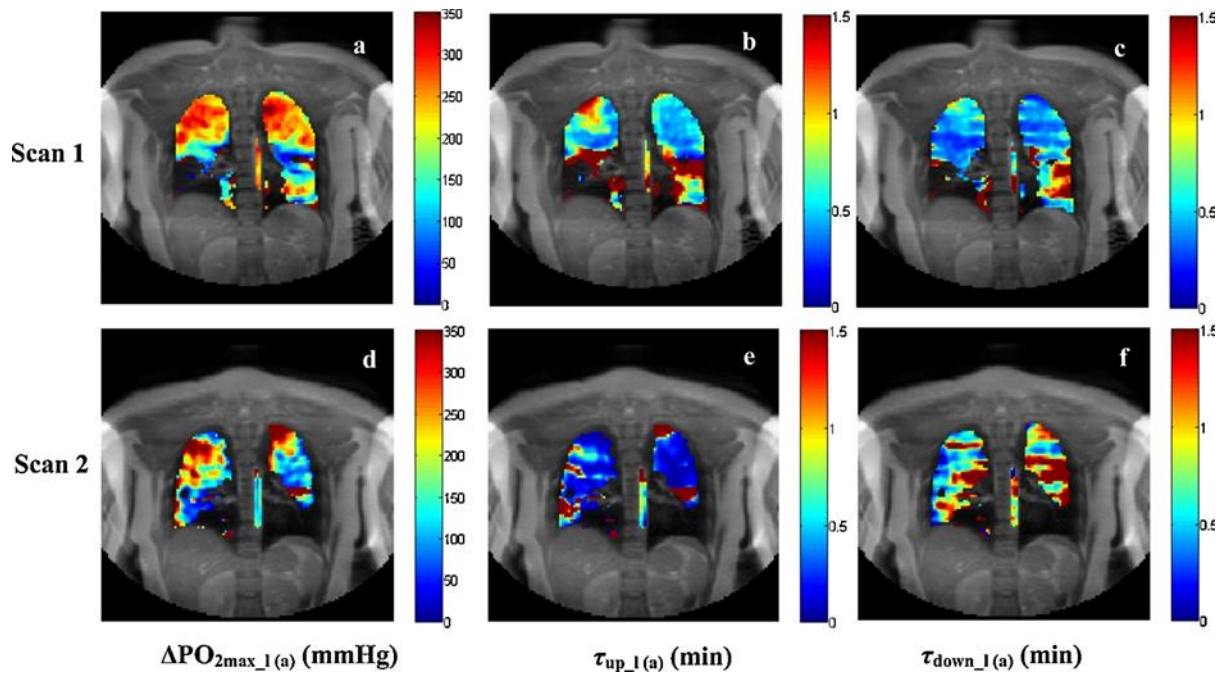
Dynamic maps of OE-MRI parameter for a severe asthmatic patient (female, 19 years old, FEV₁% predicted= 64%). The enhancing fraction in the first is 82% scan and in the second scan is 67%. EF is the enhancing fraction, $\Delta\text{PO}_{2\text{max_l}}$ is the maximal change in the partial pressure of oxygen in lung tissue and arterial blood of the aorta ($\Delta\text{PO}_{2\text{max_a}}$), ($\tau_{\text{up_l}}$, $\tau_{\text{up_a}}$) is the oxygen wash-in, and ($\tau_{\text{down_l}}$, $\tau_{\text{down_a}}$) is wash-out (Zhang et al., 2015).
